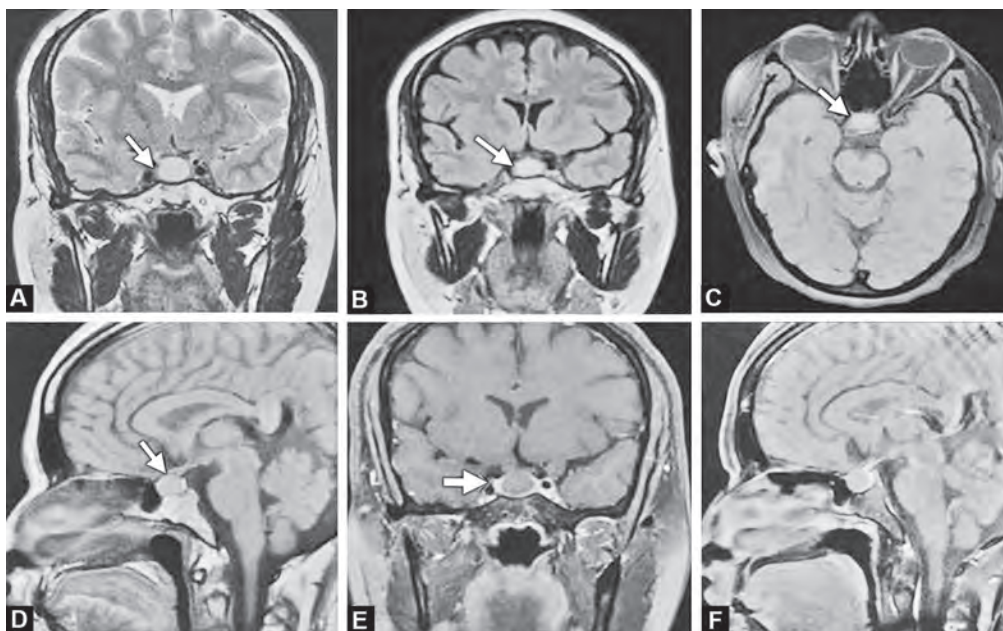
(A) Coronal T2WI, (B) Coronal T2 FLAIR, (C) Axial FLAIR, (D,E,F) Sagittal T1, coronal and Sagittal post-contrast T1WI of brain shows a well-defined T2/FLAIR hyperintense, T1 isointense lesion expanding the sella (thin arrow). The lesion shows no post-contrast enhancement. The normal pituitary gland is noted to be compressed and displaced peripherally by this lesion (thick white arrow in Fig. E)
